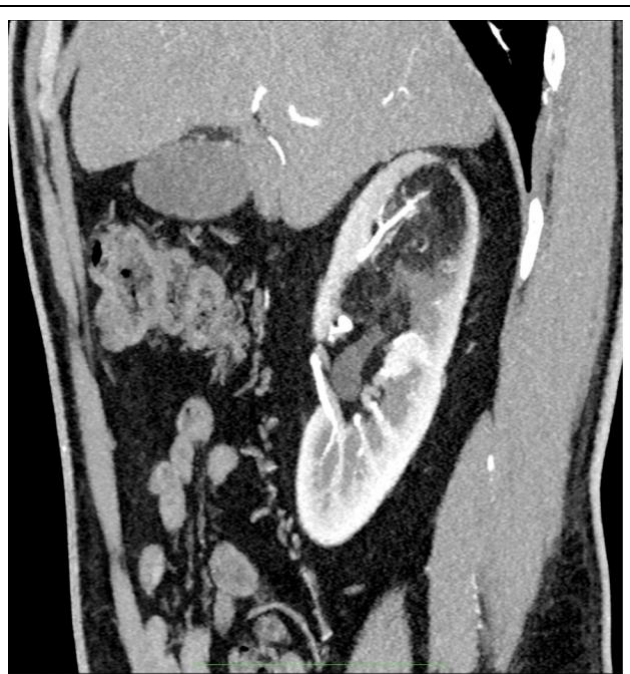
Contrast-enhanced sagittal CT images show a feeding artery from right renal artery supplying to the fat containing renal mass at upper pole of right kidney.
